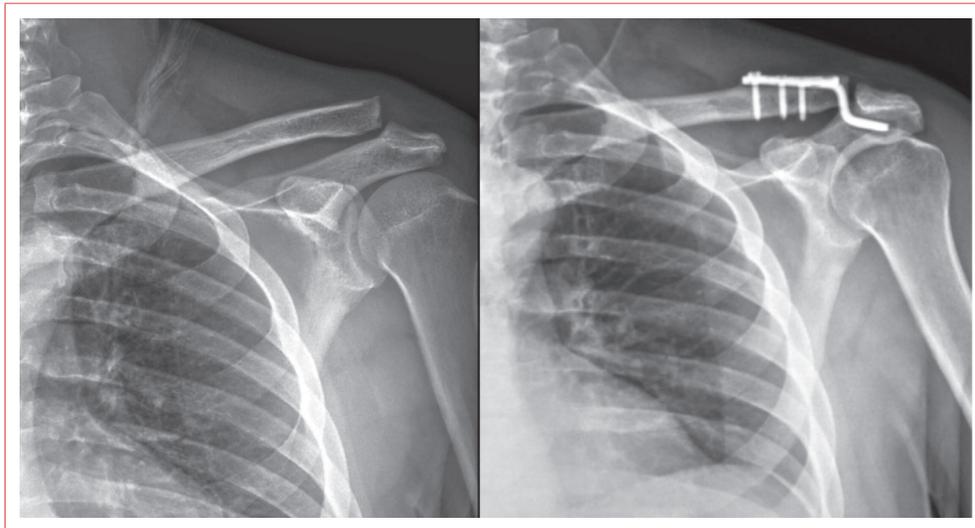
Pre-operative and post-operative X-rays of a 45-year-old male presented with Rockwood type III acromioclavicular injury, treated with hook plate.
